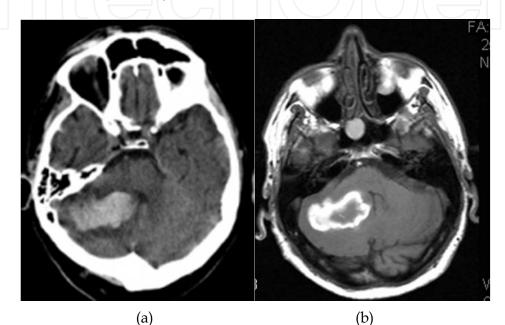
Right cerebellar hematoma in the region of the dentate nucleus. A) Axial CT shows acute hematoma with halo of surrounding edema; B) axial T1WI MR discloses the same hematoma in early subacute stage. Mass effect partially effaces the 4th ventricle.
